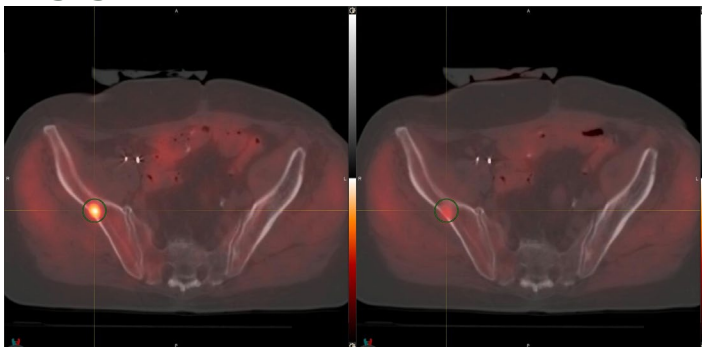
75 y/o, Gleason 7, treated with brachytherapy and EBRT 11 years previously. Rising PSA at the time of AC imaging was 11.15 ng/mL. The left image shows a focal bone metastasis in the right ilium with early imaging (SUVmax 9.06, L/B 3.28). The right image shows the same finding in the bone but is much less conspicuous on later imaging (SUVmax 5.08, L/B 2.43).
